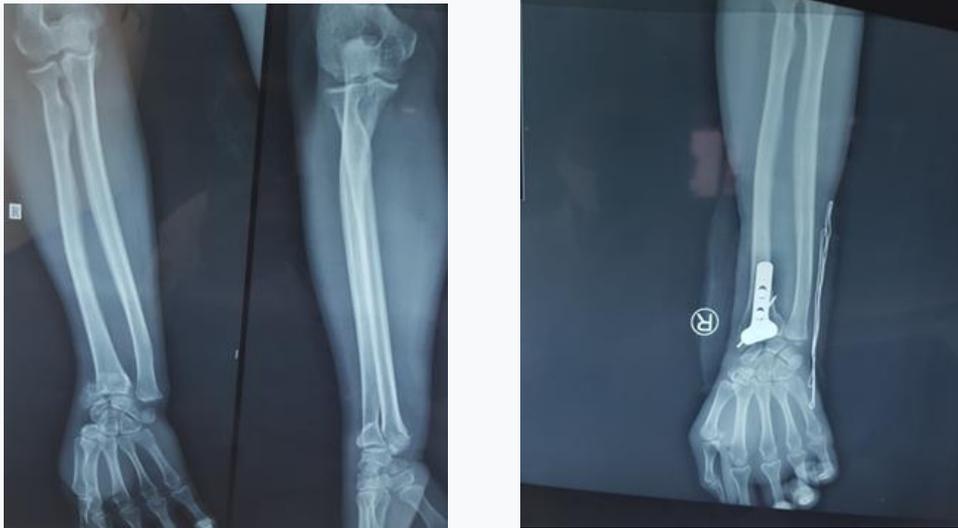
Showing some of the pre and postoperative x-rays AP and Lateral view
